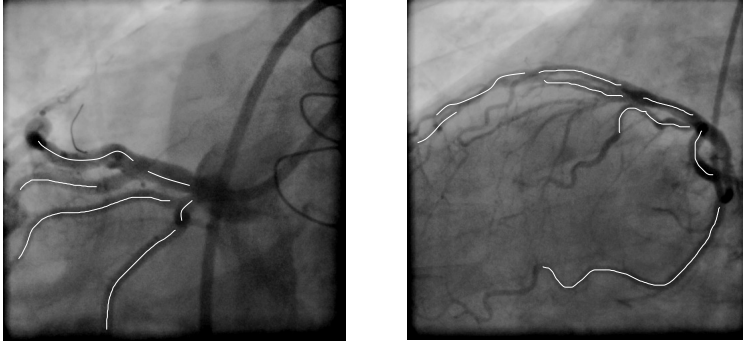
Examples of manual annotations overlaid in white on the corresponding X-ray image.
